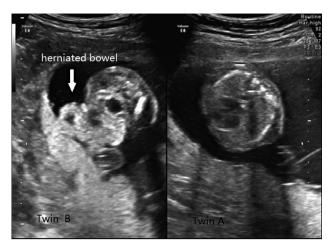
Twenty weeks' ultrasound shows anterior abdominal wall defects of twin B other than twin A.
